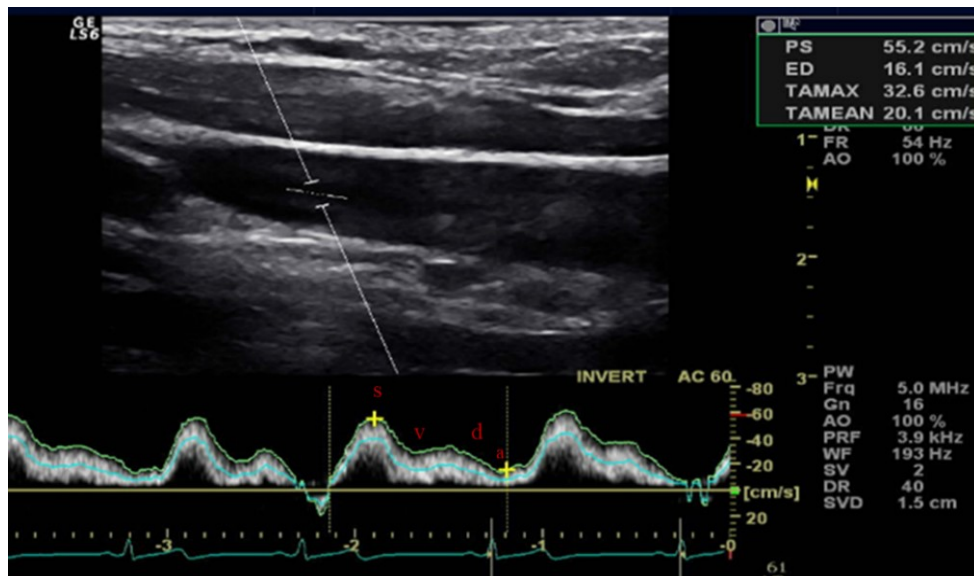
Doppler spectrum waves of IJV in J3. Systolic *s*, mid diastole depressed *v*, late diastole waves *d* and end diastolic slowing *a*.
